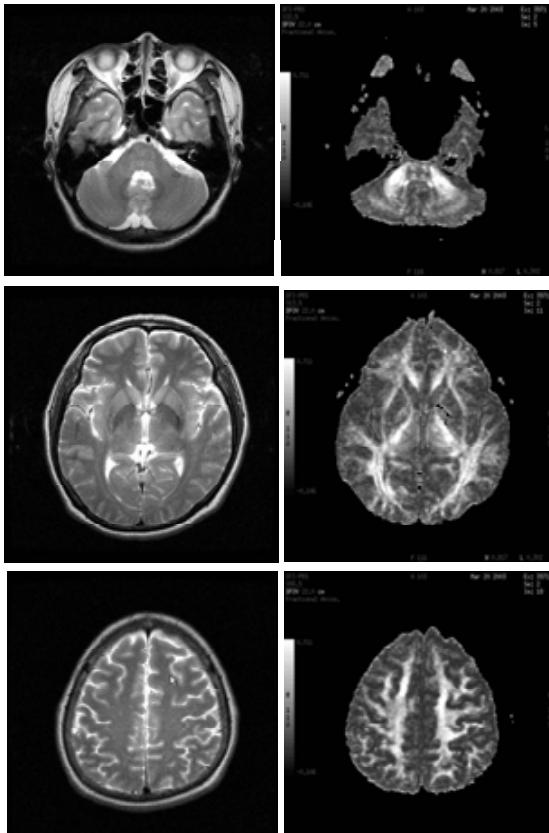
Anatomical T2-weighted images (left) and corresponding DTI images (right) for different positions in the head of a patient with tinnitus.
